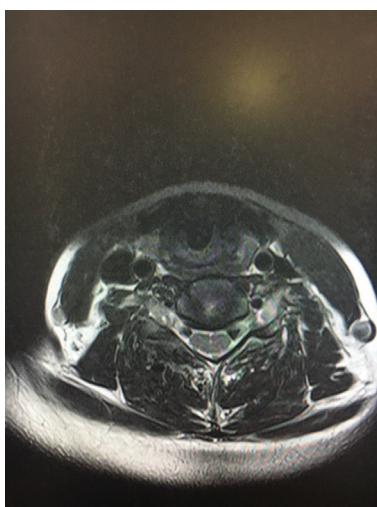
MRI cervical spine axial view C5-6 level.
